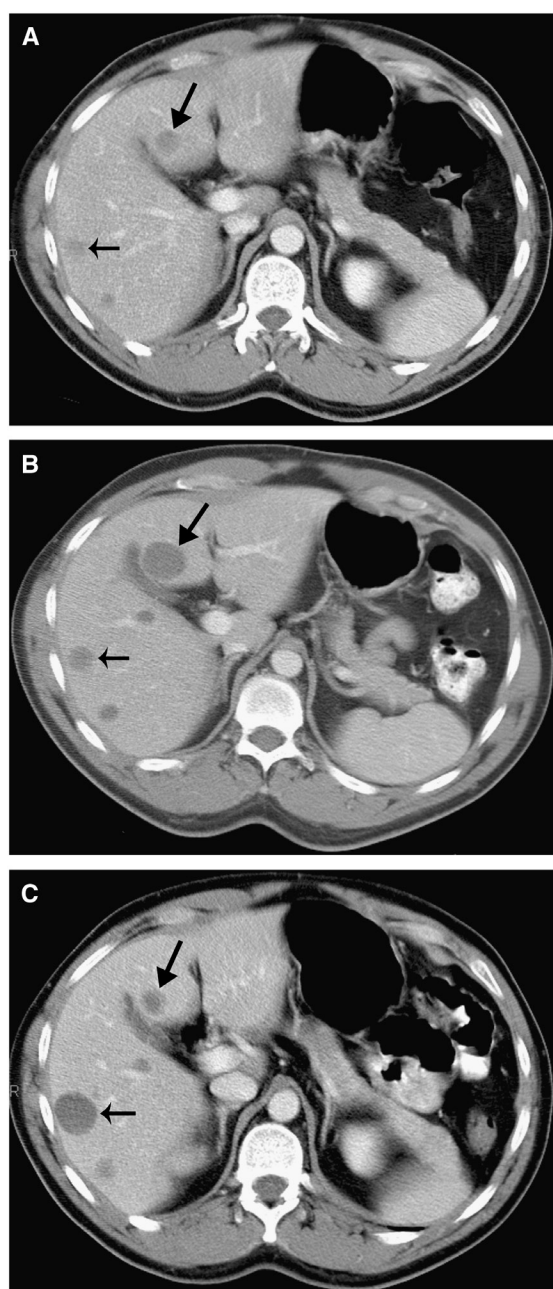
Increasing tumor size and spurious progression of disease in a 41-year-old man with a primary gastrointestinal stromal tumor of the small bowel who experienced a good response to imatinib treatment. (A) A portal-venous phase image of pretreatment CT showed multiple, small hyperdense metastases in the liver (arrows). (B) At 8 weeks after treatment, the lesions became homogenous and hypodense (indicating good response) but increased in size significantly (arrows). (C) At 16 weeks after treatment, the lesion in the medial segment of the left lobe decreased significantly (large arrow). Notice the lesion in the right lobe (small arrow) had continuously increased but remained hypodense. This lesion became smaller on follow-up CTs (not shown).
